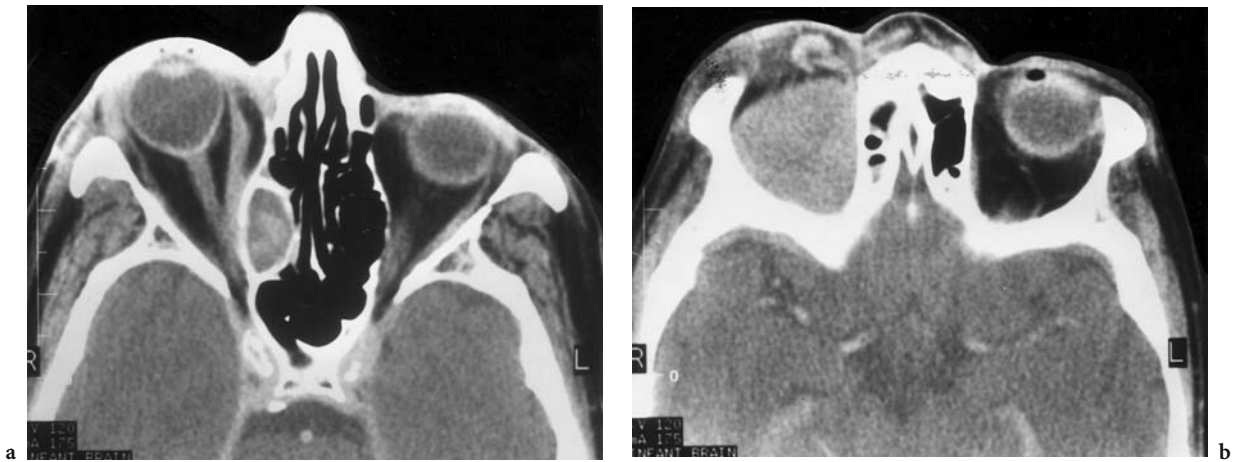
A 49-year-old man with acute, complete vision loss of the right eye. Diagnosis: pyocele of the right ethmoid with spontaneous ipsilateral subperiosteal hematoma. CT: a Axial contrast-enhanced image with complete mucous filling of the middle, characteristically widened right ethmoidal cells, and marginal contrast enhancement. Note the significant protrusion of the right eye. b Axial contrast-enhanced view at the level of the superior ophthalmic vein with an isodense, homogeneous mass. c Coronal view showing the subperiosteal mass in the superior orbit with the characteristic, sharp margin of the space-occupying formation. The absence of contrast enhancement both in the mass and at its margin leads to the suspicion of hematoma, and to the exclusion of the presence of a subperiosteal abscess
